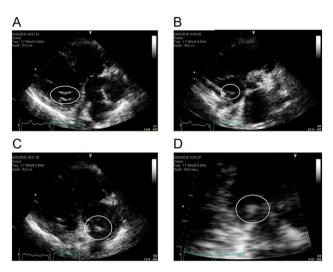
Transthoracic echocardiography images. (A) A two chamber view, long axis parasternal with posterolateral wall close to the LV lead. An echogenic mobile mass is circled. (B) A short axis view showing dilated right atrium and right ventricle with an echogenic mass circled. (C) An apical four chamber view, pacing lead can be seen at the right atrium encircled with an echogenic mass crossing the tricuspid valve. (D) A zoomed image C.
